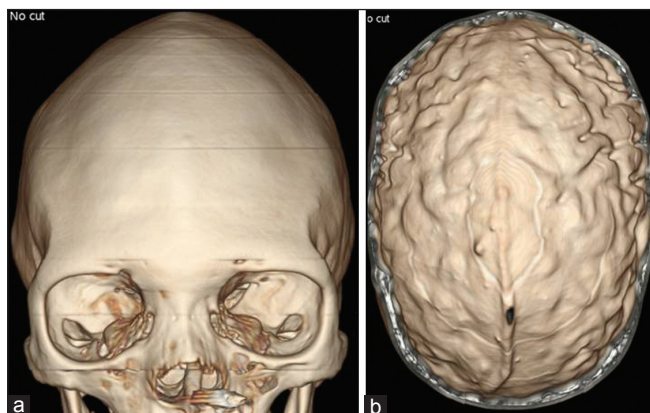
Volume-rendered computed tomography (CT) image (a) shows deformed skull with sutural closure and bone bridging and heaping. Axial cut (b) shows prominent convolutional markings on the inner table
